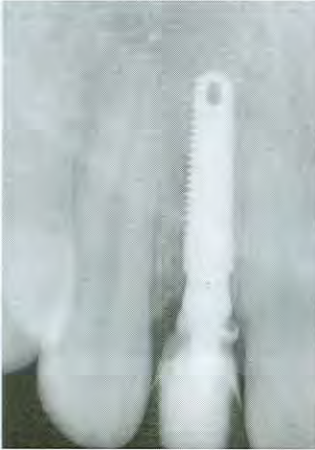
Immediate postoperative digital periapical radiograph.
